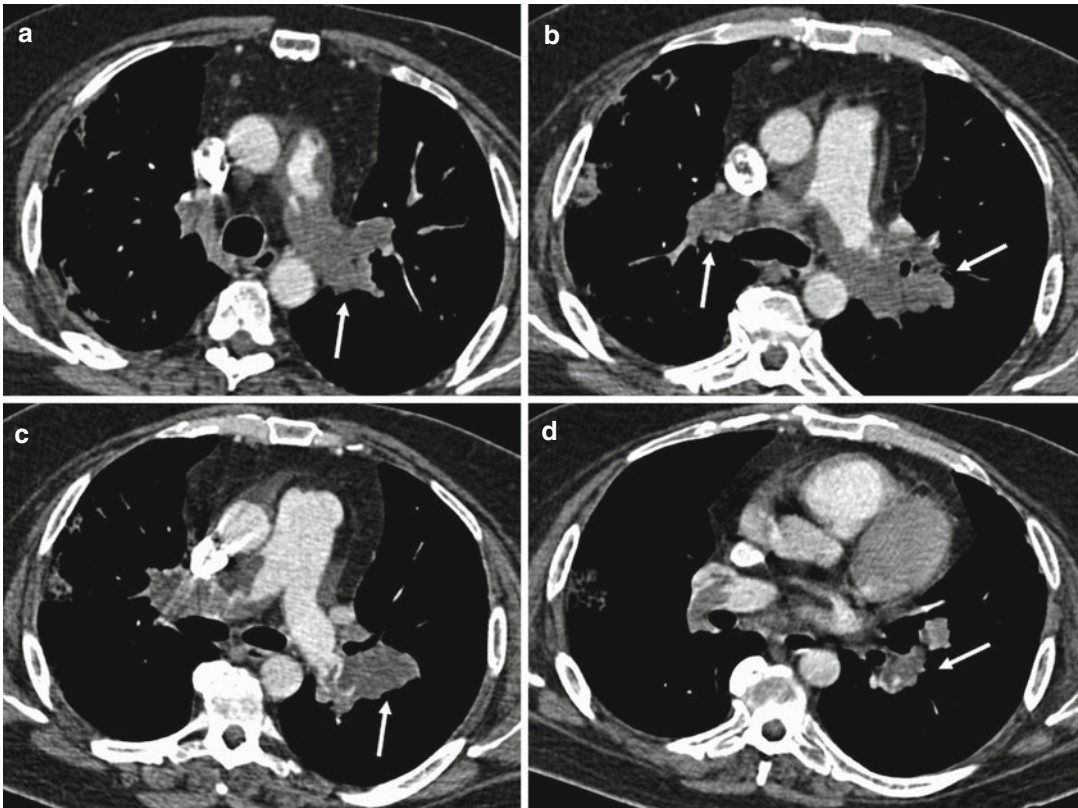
CT scans in patient with chronic pulmonary embolism showing a small recanalized left pulmonary artery with contrast material in the central lumen (*arrow-*
